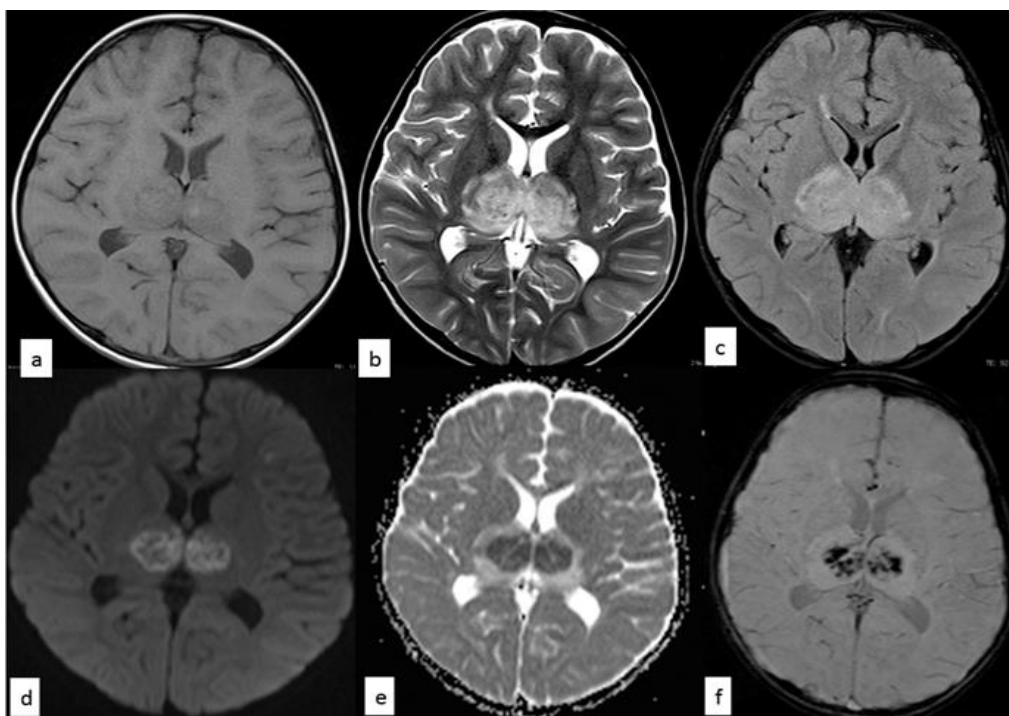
showing encephalitis pattern- Symmetrical T1 hypointense with few interspersed areas of hyperintense foci (a), T2/FLAIR hyperintensities in bilateral thalami (b, c) showing restricted diffusion on DWI (d,e) and blooming on SWI (f).
